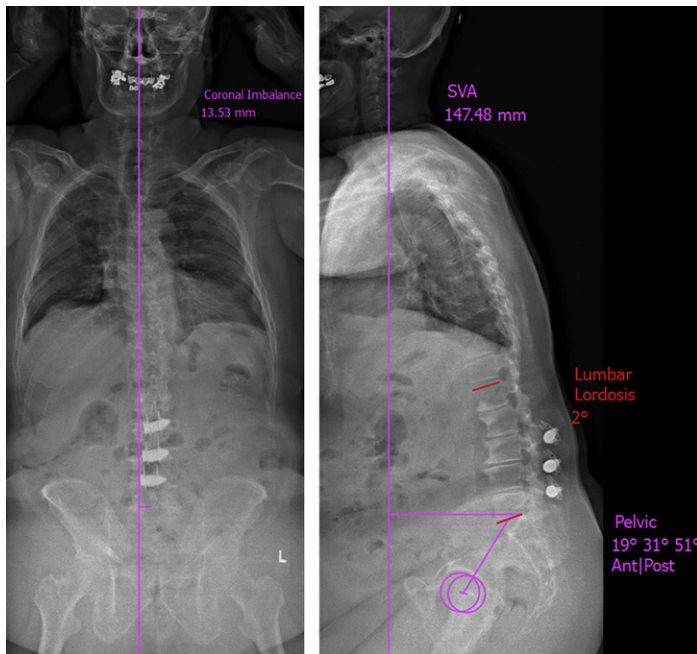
Preoperative coronal and sagittal radiographs demonstrating a severe sagittal-plane deformity in association with previously placed interspinous devices (sagittal vertical axis [SVA] = 14.7 cm, PT = 31°, and PI-LL mismatch = 49°).
